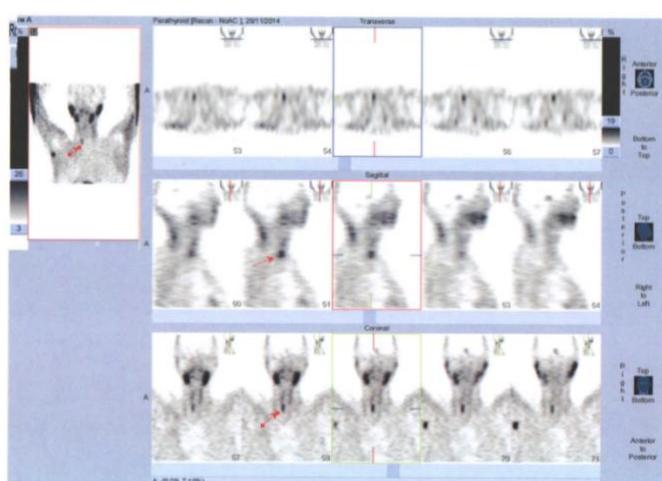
Early SPECT images showing an area of hyperfixation located in the right part of the neck.
